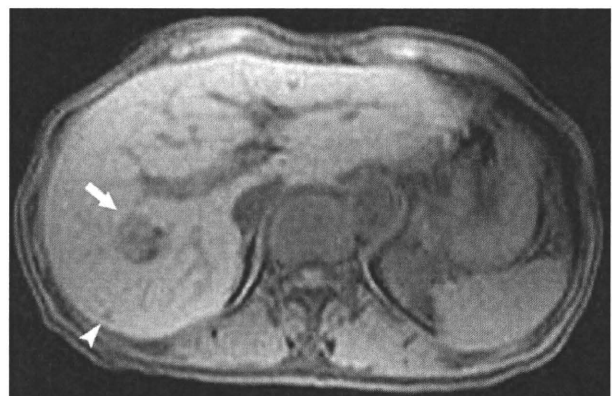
A 68-year-old woman with malignant melanoma of the anus. The patient received surgical resection and lymph node dissection. Contrast-enhanced CT showed low attenuation nodule of the liver in segment 7 which was intermediate findings. Fat suppressed transverse T1-weighted gradient-echo image obtained 3 months after operation shows two nodules with low signal intensity. The lesion is 22 mm in the diameter (arrow), and additional tiny nodule is depicted in segment 7 (arrowhead). Ultrasonographic-needle biopsy was performed for the larger nodule, and hepatic metastasis was confirmed.
